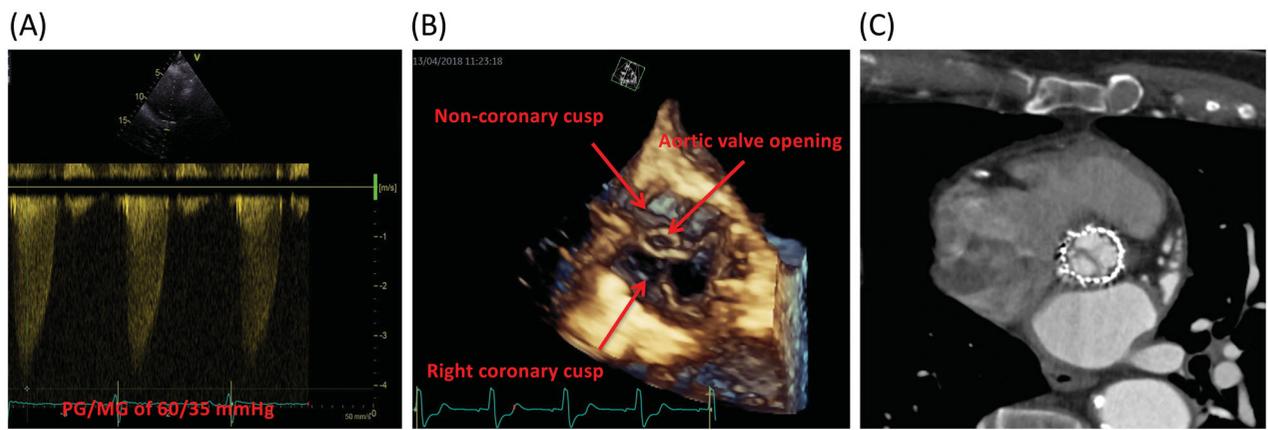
2D/3D echocardiography and cardiac scanner of the aortic valve before antioagulation treatment.
